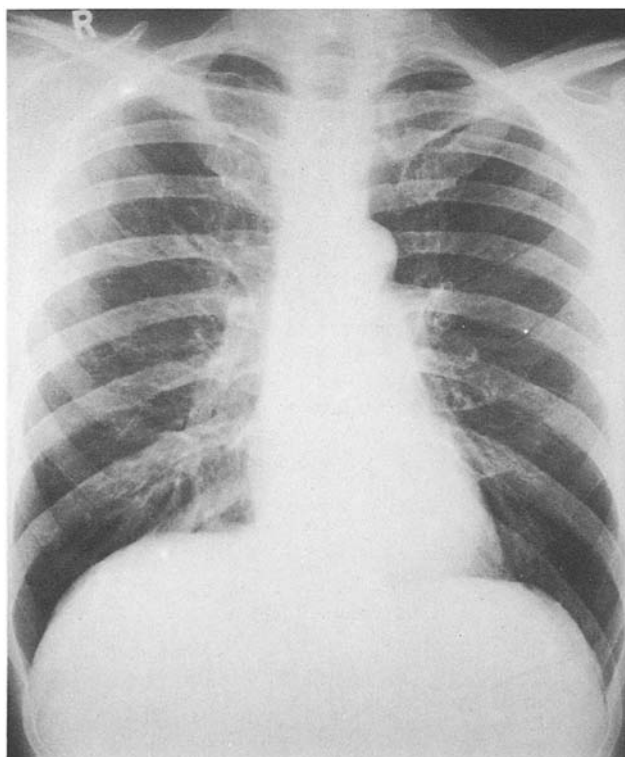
Chest X-ray of case no. 14, 18 weeks after starting chemotherapy
